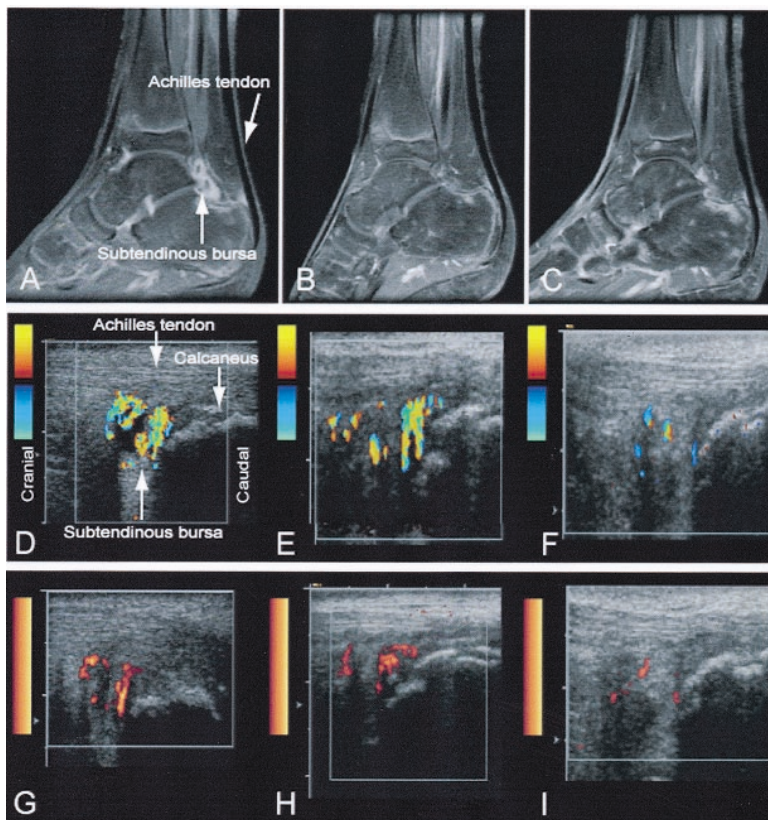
Panels A–C represent sagittal T1-weighted MR images of the right ankle following contrast administration (A) before, (B) at 6 months, and (C) 1 year after starting etanercept. Enhancing thickened synovitis at the tibiotalar and subtalar joints is seen at baseline (A). At 6 months, improvement with minimal residual synovitis enhancement and some enhancement in the superior aspect of the posterior calcaneus is visible (B). The 1-year followup imaging shows complete resolution of synovitis (C). Color (D–F) and power (G–I) Doppler sonograms of the posterior aspect of the right ankle are shown at baseline (D, G) and 6 months (E, H) and 1 year (F, I) after start of therapy. Although significant improvement of joint effusion at the posterior recess of the ankle is visible within the first 6 months, persistent synovial hyperemia is still seen at 6 months (E, H). Significant reduction in the degree of synovial hyperemia of the ankle is seen on color (F) and power (I) Doppler sonography only 1 year after the start of therapy.
